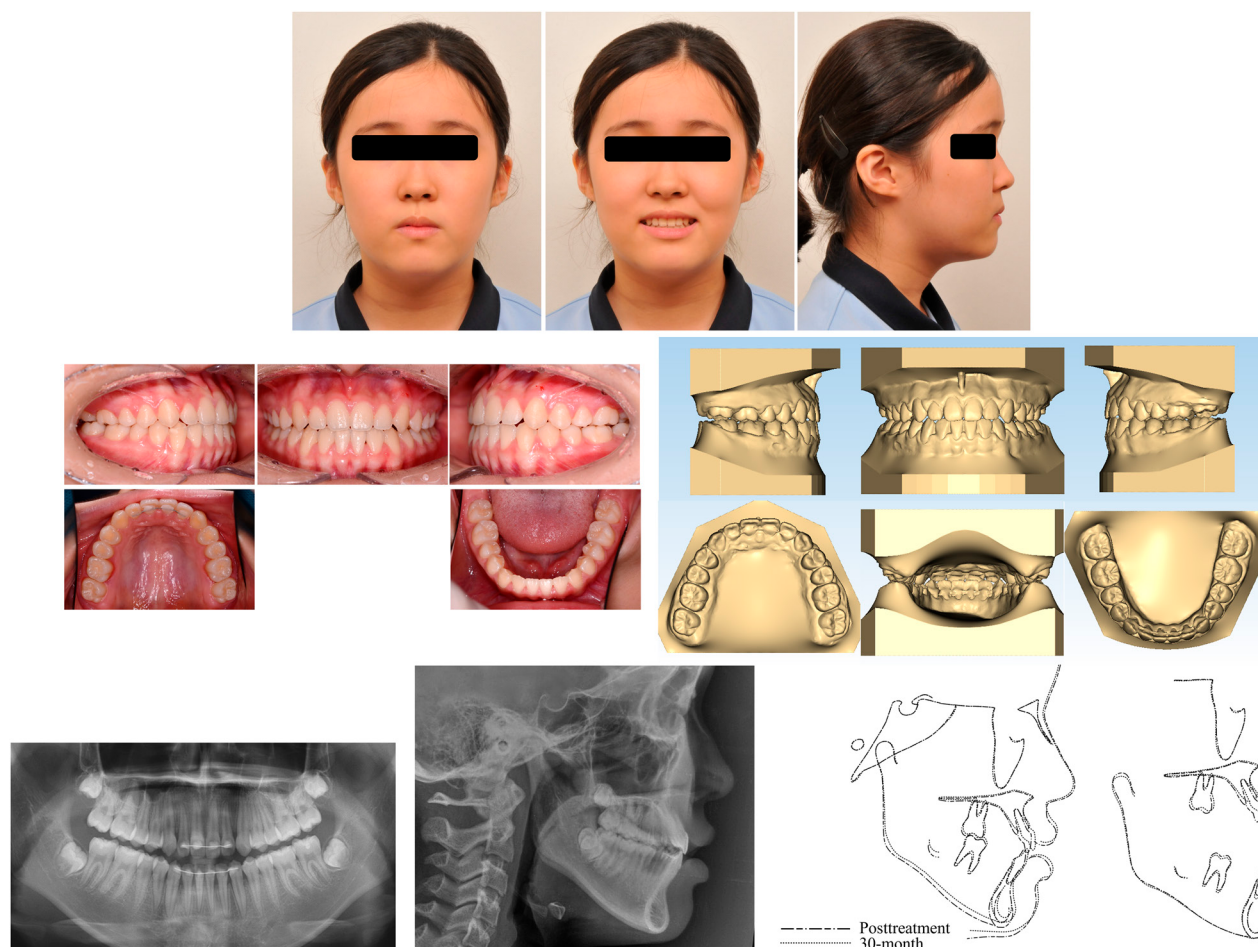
Post-treatment records, including extraoral and intraoral photographs, three-dimensional virtual model, panoramic radiograph, cephalogram, and superimposition of radiographs taken at 30 months of treatment and post-treatment. All post-treatment records were taken after debonding braces.
